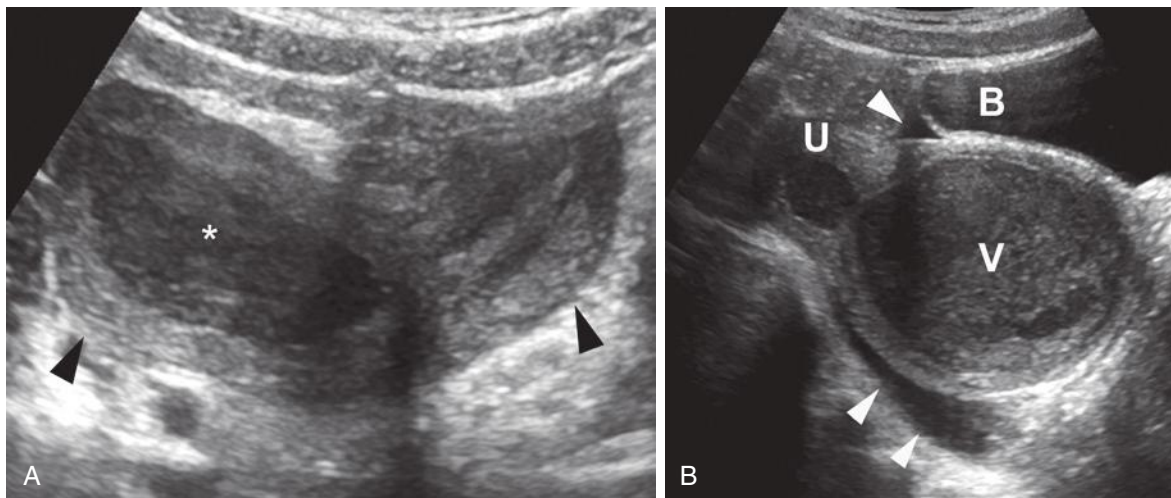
Uterus didelphys in a 12-year-old girl with chronic pelvic pain. A, Transverse ultrasound image shows two widely divergent uterine horns (*arrowheads*). The right uterine horn is distended with hypoechoic material consistent with blood (*asterisk*). B, Right parasagittal ultrasound image demonstrates an obstructed vagina (V) filled with blood. There is a small amount of free fluid in the cul-de-sac and above the bladder (*arrowheads*). B, bladder; U, uterine fundus. The left vagina was normal (not shown).
